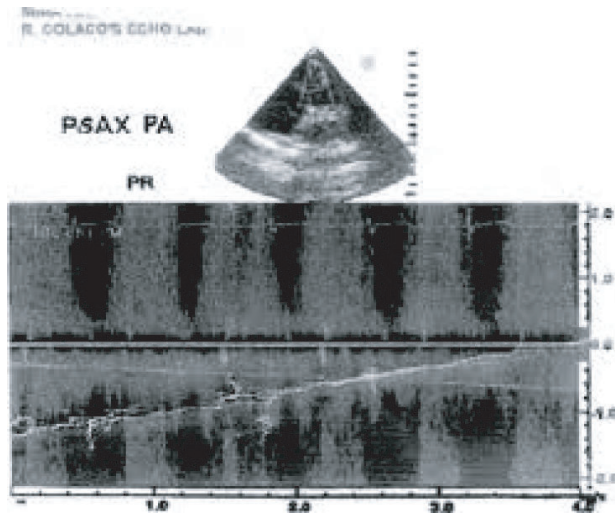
Transthoracic echocardiogram in parasternal short axis (PSAX) view
